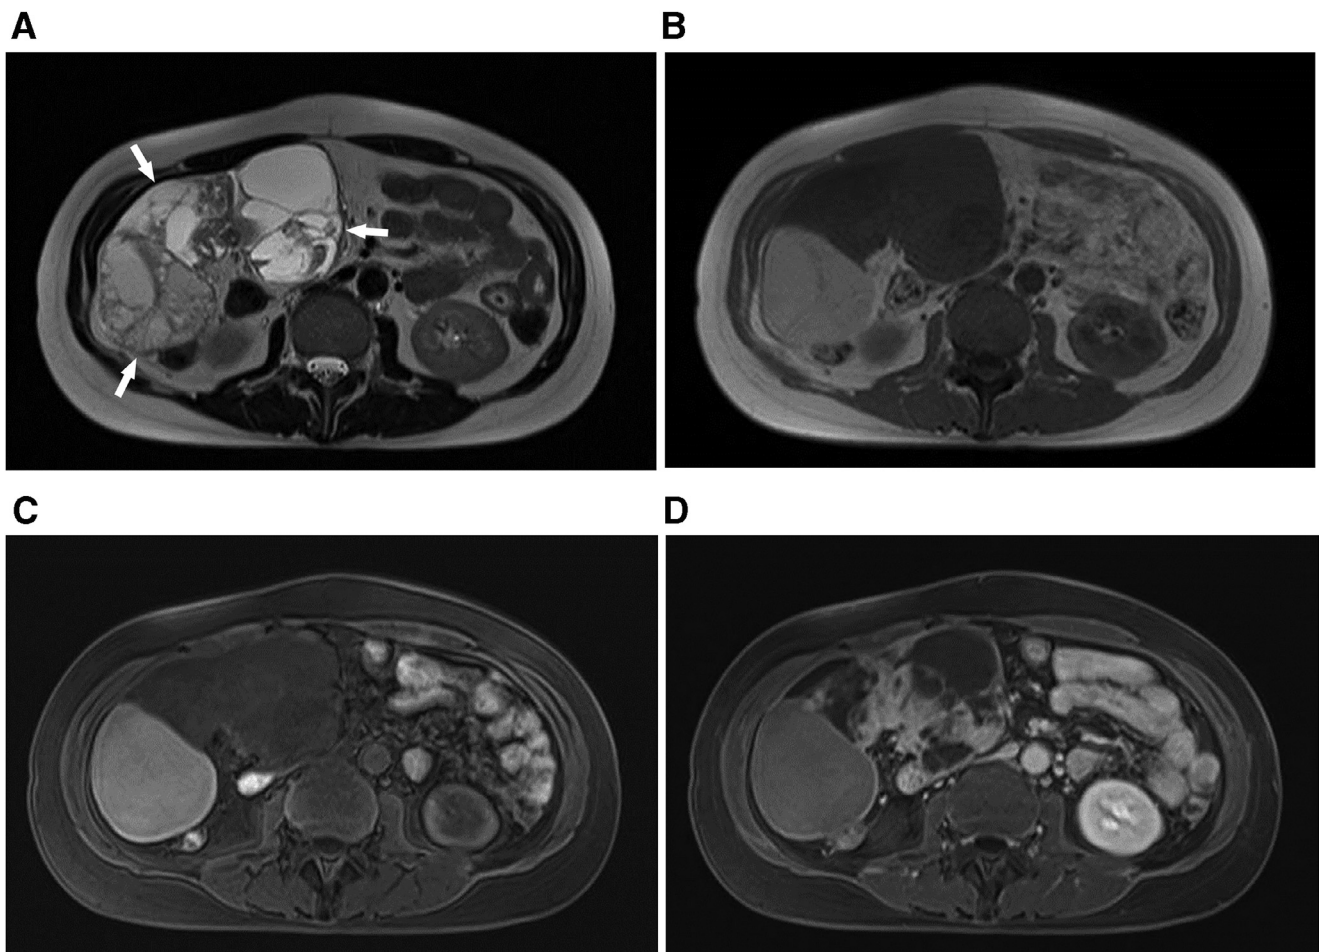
(A) MRI clearly revealing the patient’s multilocular cystic mass with very high intensity on the T2-weighted image. The signal in the cysts was variable, and some of the cysts showed high intensity on T1-weighted imaging (B) with fat suppression (C), suggesting blood or viscous protein components. (D) Gadolinium-enhanced T1-weighted image with fat suppression showing heterogeneous contrast enhancement at the irregularly thickened walls and septum.
